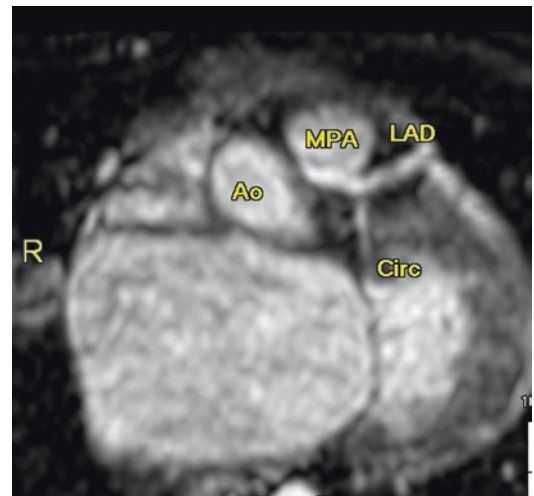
MRI image showing the origin of the left coronary artery off the main pulmonary artery (MPA) and its bifurcation into the left anterior descending artery (directed anteriorly) and the circumflex (directed posteriorly). Ao aorta
